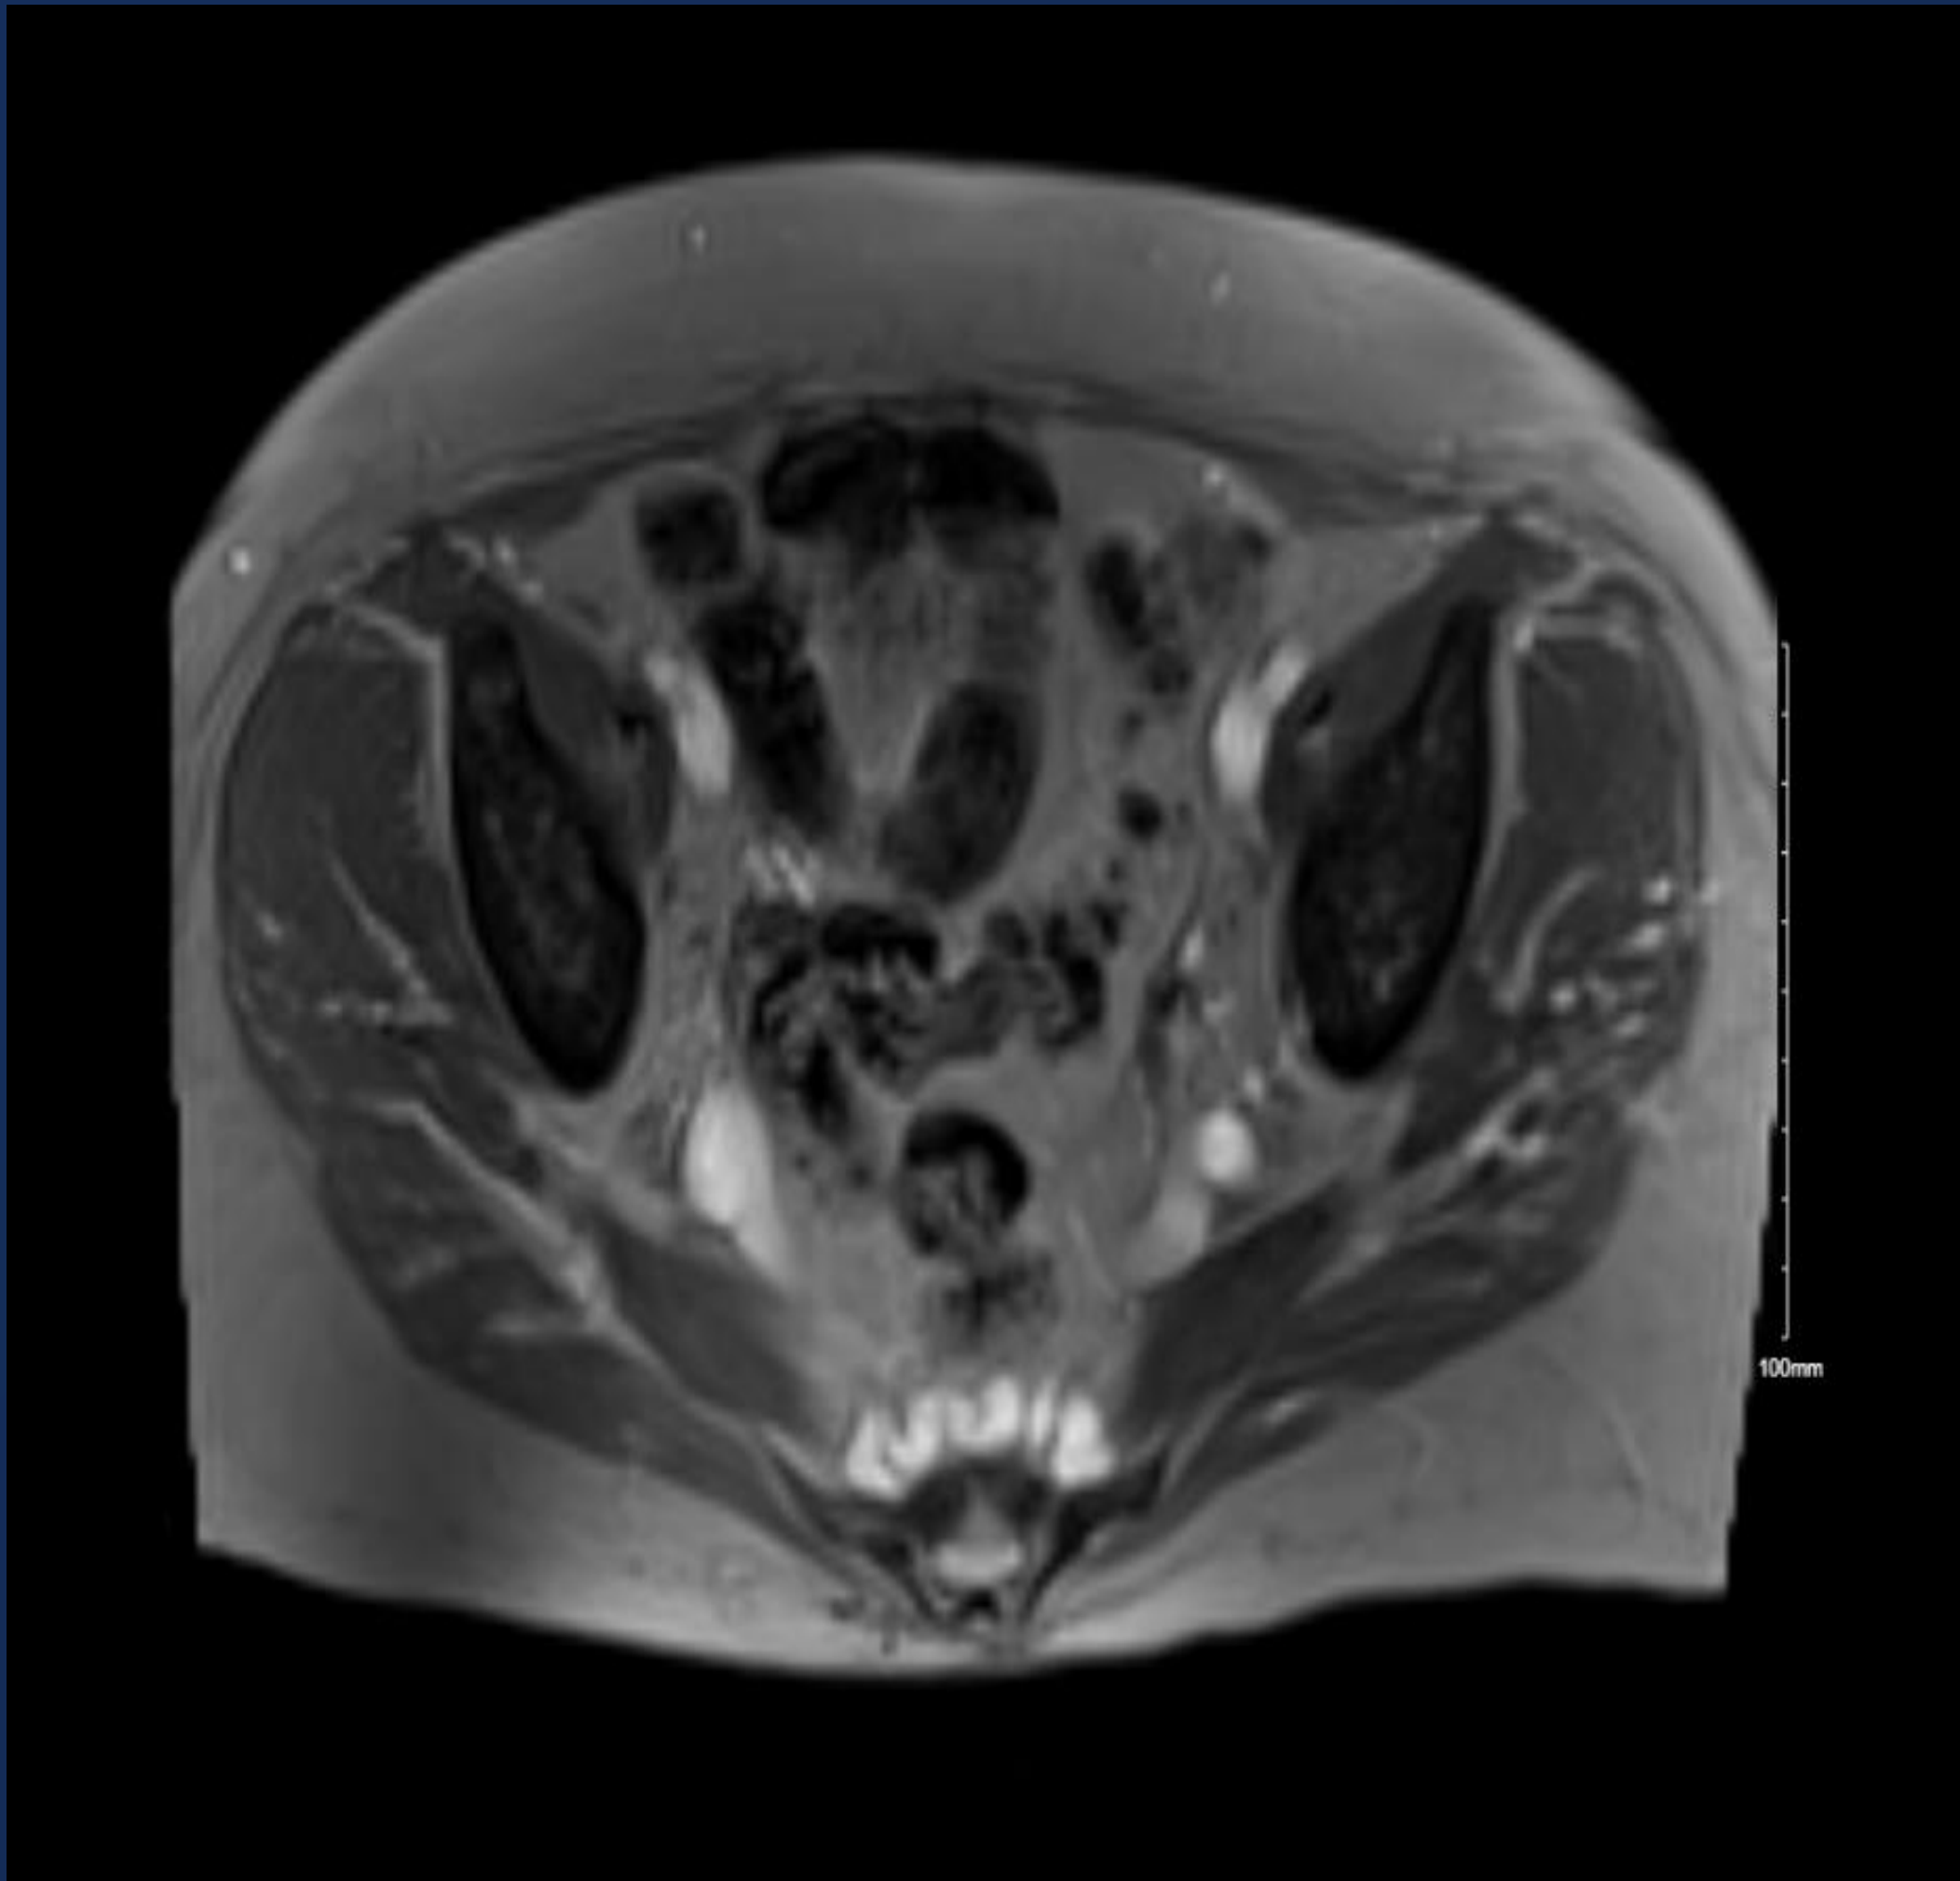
Pre-intervention MRI demonstrating large presacral and pre-coccygeal varicosities extending across midline
